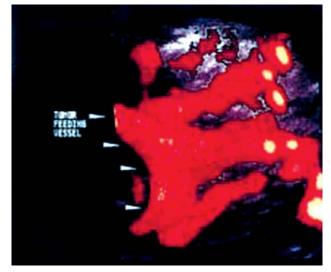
Three-dimensional power Doppler scan of a malignant tumor neovascularization. Note the three generations of the vessels, areas of stenosis, microaneurysms and tumoral lakes
